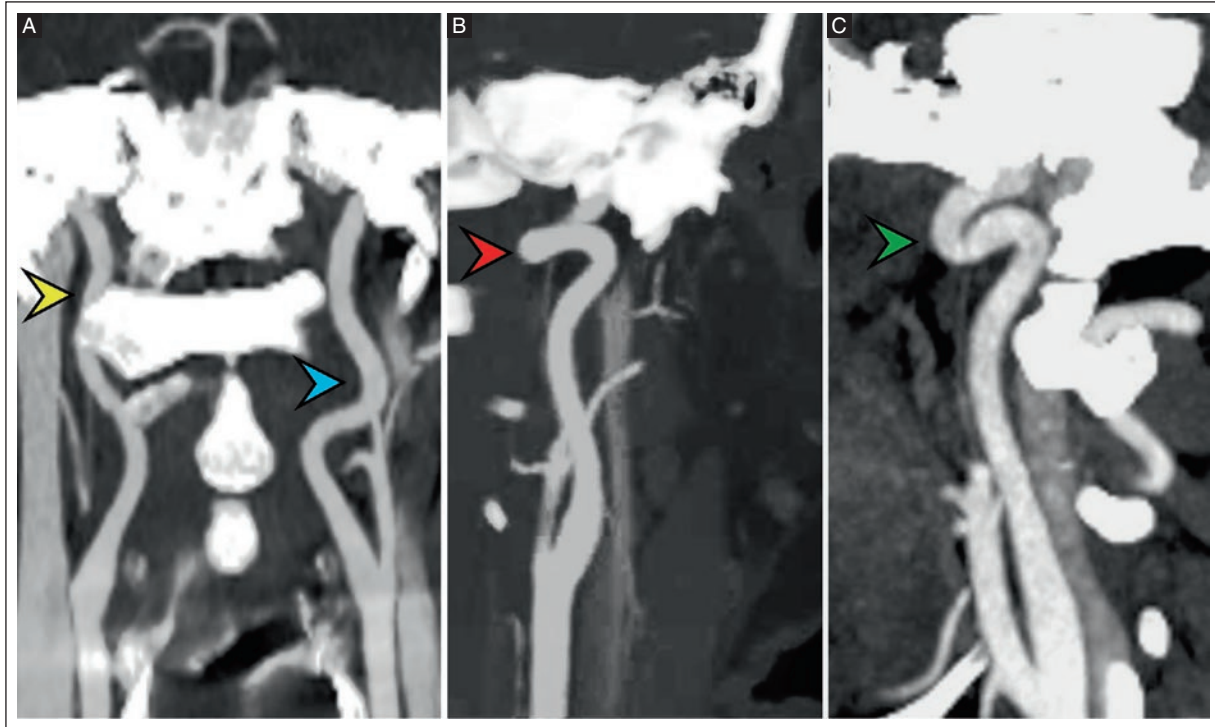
Neck CTA examinations showing different EICA dolichoarteriopathy types. A: coronal neck CTA reconstruction from a 41-year-old man showing tortuosity type in the right (yellow arrowhead) and left (blue arrowhead) EICA. B: coronal-oblique CTA reconstruction from a 23-year-old man with coiling type of the left EICA (red arrowhead). C: a sagittal CTA reconstruction from a 47-year-old woman showing kinking type of the left EICA (green arrowhead).
